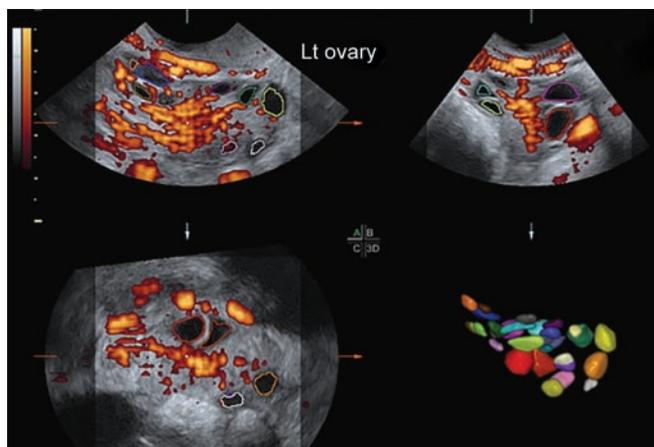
Three-dimensional ultrasound volume of the ovary with Sono AVC, color coding the antral follicles
